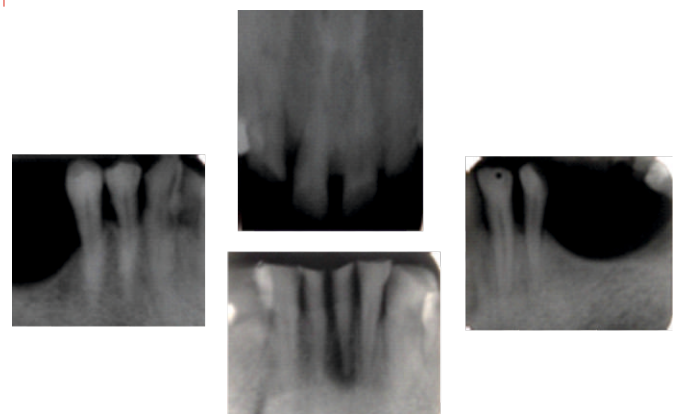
Radiographic examination at the time of consultation
